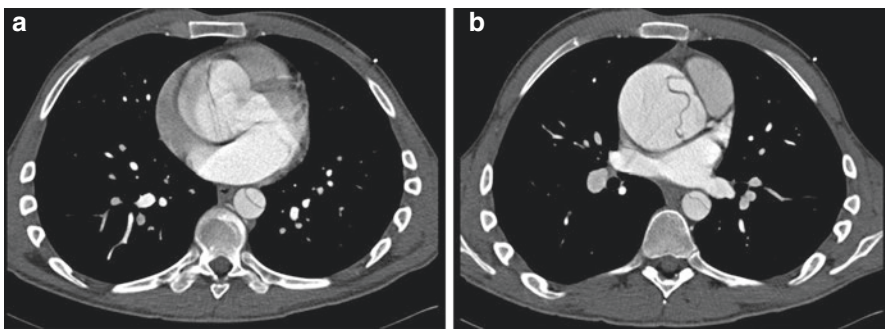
Preoperative CTA demonstrating a dilated aortic root with the dissection flap extending into the aortic root (a) and the ascending aorta (b)
